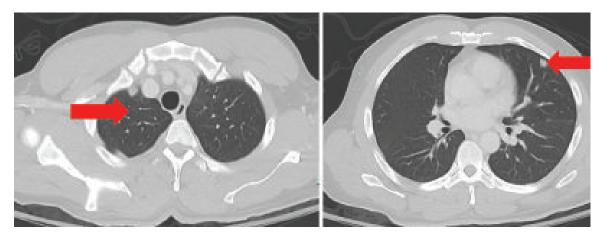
CT chest, abdomen and pelvis revealed numerous bilateral pulmonary nodules, indicating metastasis.
